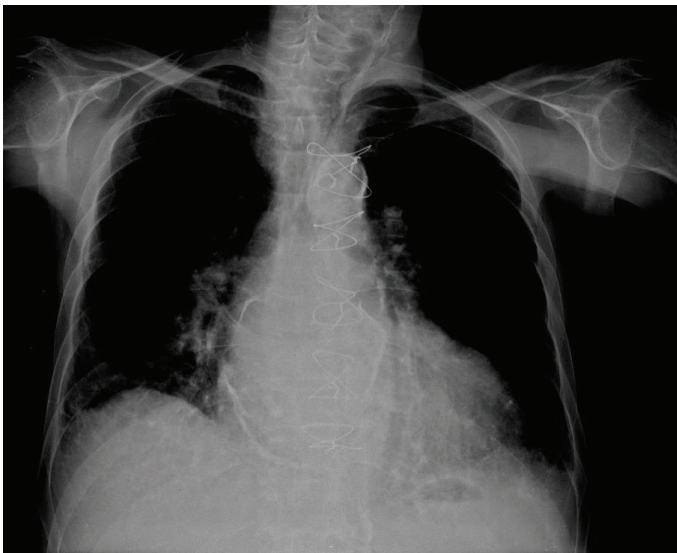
Chest radiography showing diffuse calcified outline of the left atrial wall
